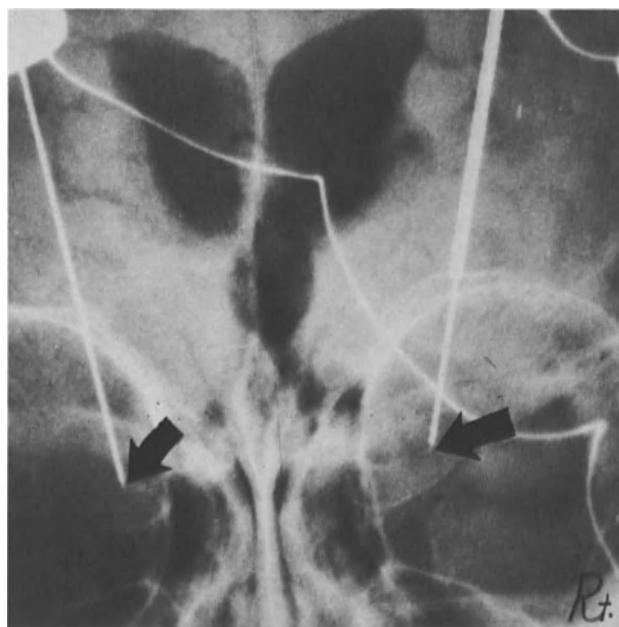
A & B. Two needles inserted into the amygdala of each side referring to the figure of the temporal horn on X-ray.
